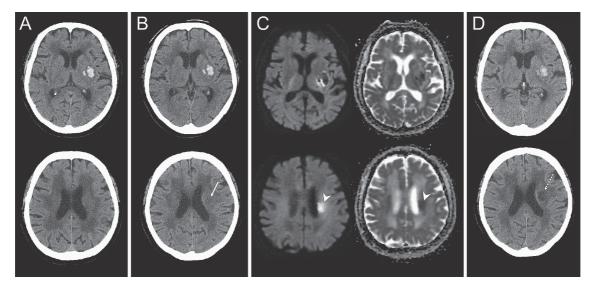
Chronological findings on neuroimaging. A, Computed tomography (CT) on admission (Day 1) showing a small left hemorrhage confined within the putamen; B, Follow-up CT on Day 2. The hematoma had not changed in size, but the density of the left corona radiata adjacent to the hematoma had lowered slightly (*arrow*); C, Diffusion-weighted imaging (*left*) and apparent diffusion coefficient maps (*right*) on Day 6 revealing acute cerebral infarction in the left corona radiata (*arrowheads*); D, Follow-up CT on Day 9 showing a clear low-density area (*dotted arrow*) corresponding to the corona radiata infarction on magnetic resonance imaging.
